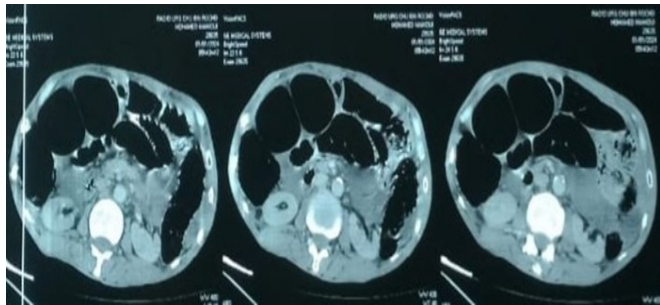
CT scan showing the distension of the colonic frame
